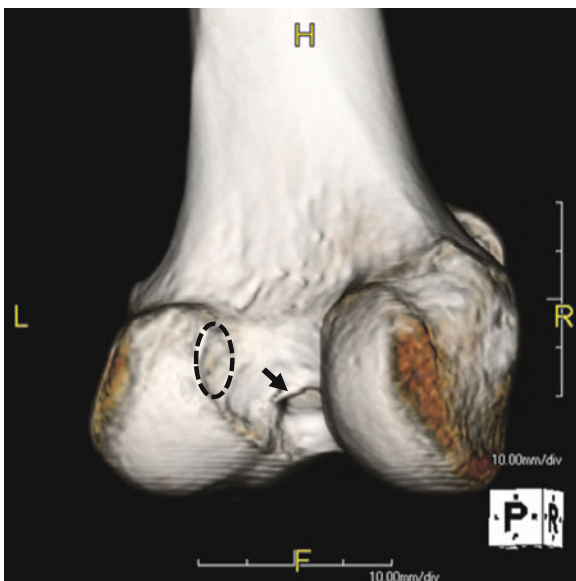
CT scan showing an anterior ACL tunnel at the roof of the intercondylar fossa. The *dotted circle* shows the anatomical position of the femoral ACL insertion. The *arrow* shows the malpositioned ACL tunnel at the roof of the intercondylar fossa.
